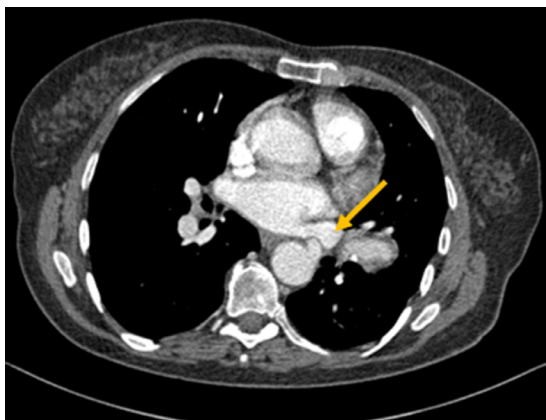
Axial contrast-enhanced computed tomography (mediastinal window) shows the venous return to the left atrium in relation to the pulmonary veins.
